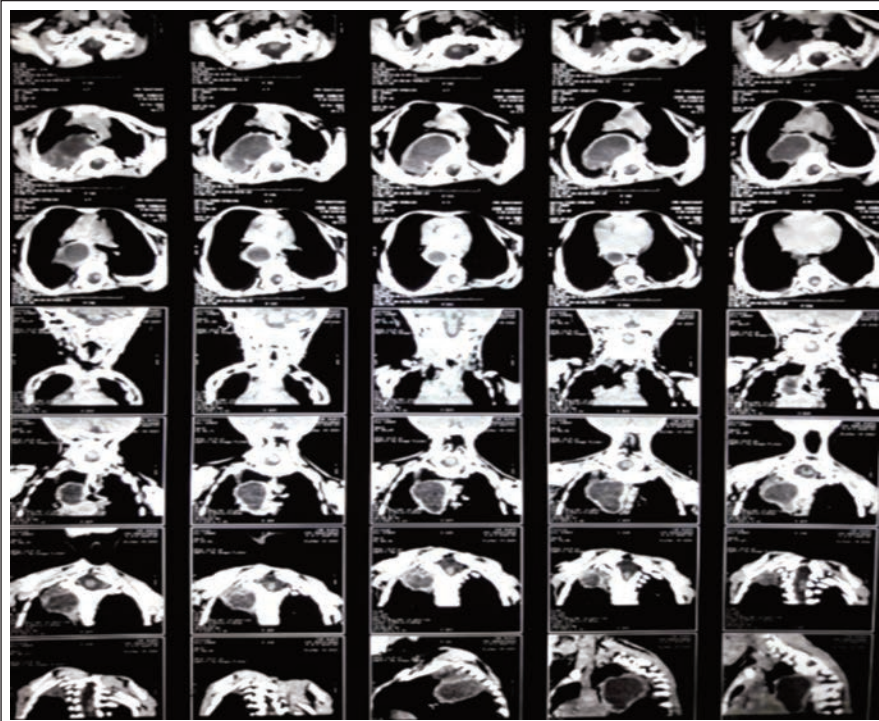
HRCT chest: Showing a large well-defined fluid density area with a thick wall in the posterior mediastinum on the right side of the oesophagus measuring 4.0 x 3.9 x 3.2cms and extending towards the right. Anteriorly, it is compressing the trachea and the right main bronchus near the carina displacing them anteriorly & medially displacing the thoracic mediastinum. Posteriorly it is extending up to the posterior chest wall. A spina bifida with spinal canal diameter at the level of 19mm is present. There is widening of spinal canal at Cervical 2 to Thoracic 4 level.
